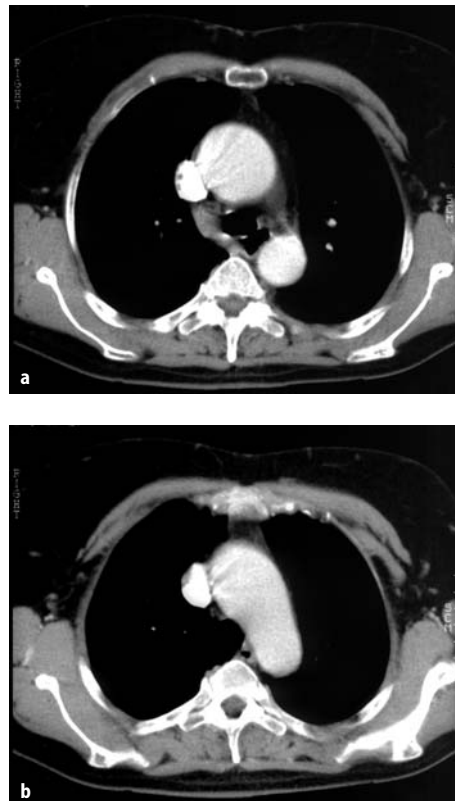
Typical computed tomography of the chest with contrast in a 65-year-old patient with a true proximal aortic aneurysm. The main involvement is in the ascending aorta, and this patient can be treated by ascending and partial arch replacement
